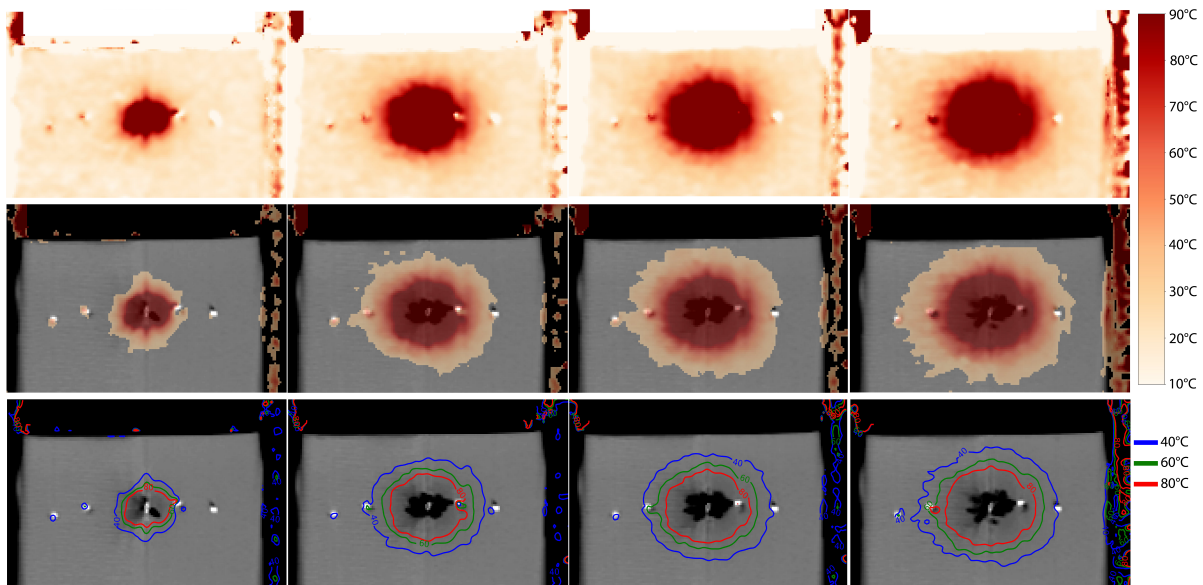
This figure presents three methods for visualizing temperature data as acquired with CT during a thermal ablation procedure. The temperature data was obtained using physical density-based thermometry at an energy level of 150 keV, without metal artifacts reduction. The images shown are after 60, 300, 450 and 600 seconds of ablation. The top row depicts thermal maps with a temperature range of 10°C to 90°C. The middle row integrates the thermal map onto the CT images, highlighting regions where the temperature has exceeded 30°C. The bottom row delineates regions of specific thermal significance on the CT image, with isolines at temperatures of 40°C, 60°C, and 80°C. To improve image quality, bilateral filtering was employed on the density maps used to derive the temperature data. This visualization approach assists physicians in accurately delineating the ablation zone.
